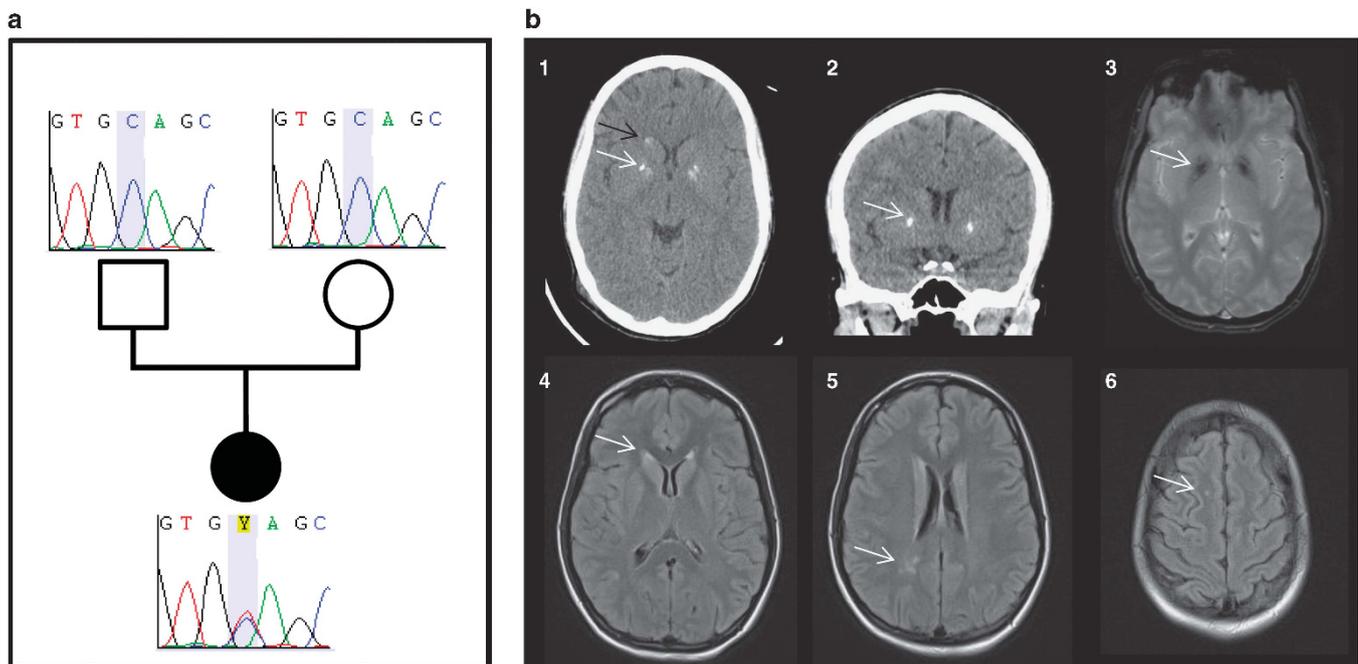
Electropherograms and brain imaging. Electropherograms show a heterozygous substitution of a C by a T in the proband, and a wild-type allele (C) in both parents (a). Brain CT scans on axial (b-1) and coronal (b-2) views show moderate calcifications in the lenticular nuclei (white arrows) and faint calcifications in the caudate nuclei (black arrow). On T2-weighted MRI, calcifications appear hypointense (b-3) while no signal modification is seen in the lenticular nuclei in FLAIR-weighted images, showing hyperintensities on anterior periventricular regions (b-4) and subcortical white matter (b-5, b-6).
